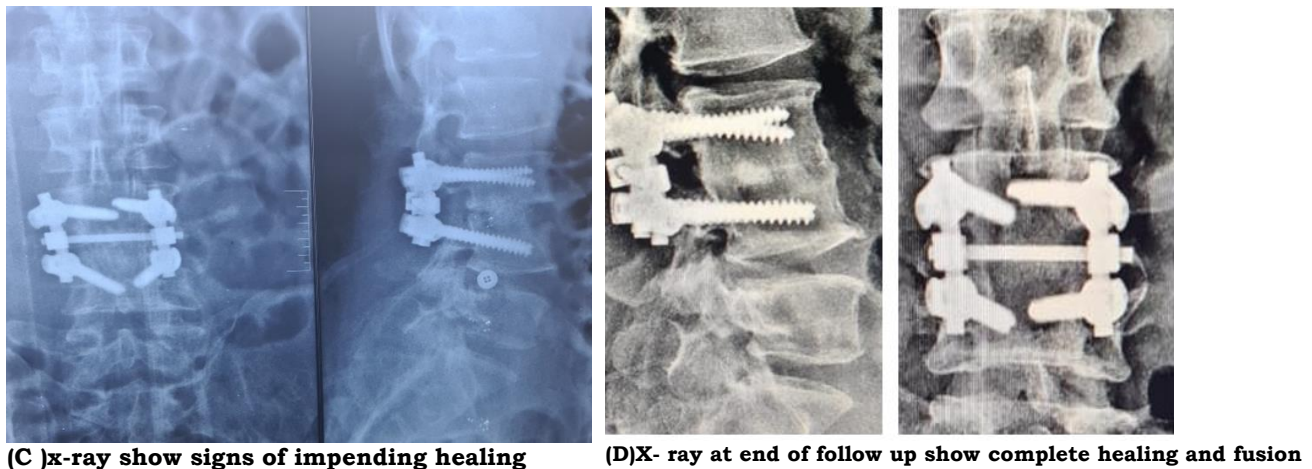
(C) 6 weeks postoperative X-ray showing signs of impending healing. (D) X-ray showing full healing and fusion
